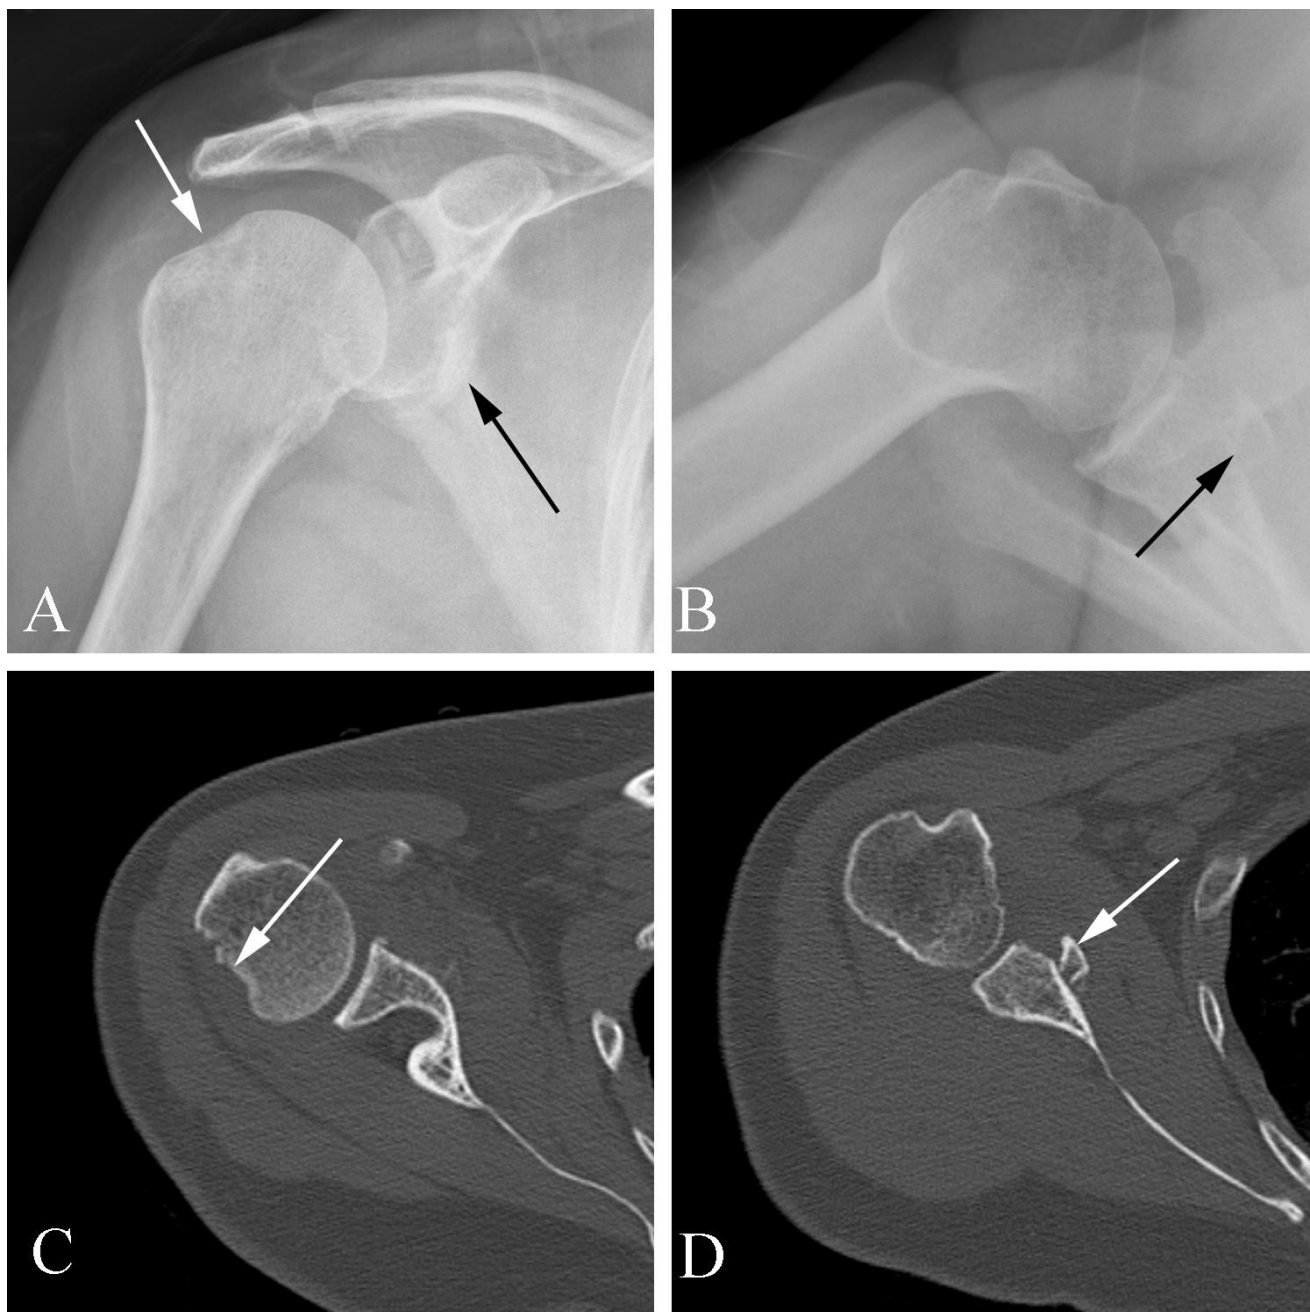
Complex shoulder fracture in a 65 year old woman with pain following trauma. A. AP plain film examination shows a “dent” in the superolateral humeral head (arrow), the Hill-Sachs deformity. B. Axial plain film examination shows discontinuity of the glenoid with a medially displaced bone fragment (arrow). C. Axial CT study at the level of the upper glenohumeral joint shows indentation of the humeral head (arrow). D. Axial CT study at the level of the lower glenohumeral joint shows a fracture of the anterior inferior glenoid rim with a medially displaced bone fragment. The imaging features are characteristic of a dislocation of the glenohumeral joint with associated fractures.
